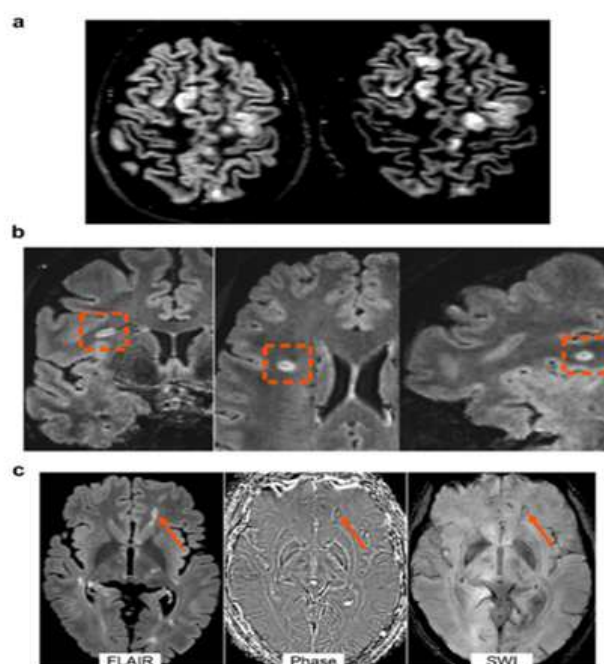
Examples of cortical lesions, the central vein sign, and persistent active lesions. (a) A patient with multiple sclerosis has several cortical lesions on a double inversion recovery sequence at 3.0 T. (b) A white matter lesion on the post-contrast T2-FLAIR* sequence at 3.0 T that displays the central vein sign (orange dotted rectangle). (c) One of the T2-hyperintense white matter lesions evident on T2-FLAIR has a hypointense ring on the phase picture and SWI sequence at 3.0 T (orange arrow). FLAIR stands for fluid-attenuated inversion recovery, and SWI is for susceptibility-weighted imaging.
